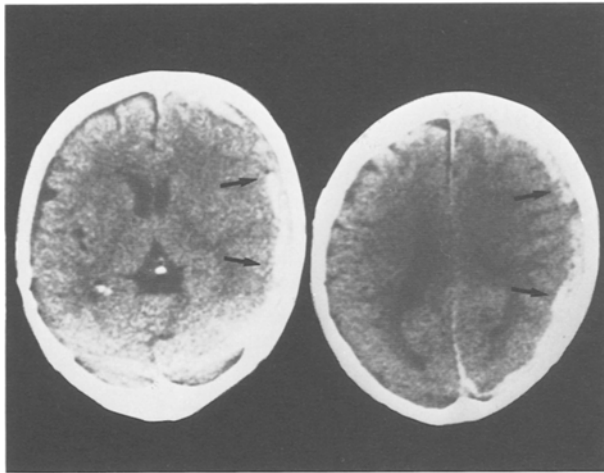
Computed tomography scans at the time of admission in case 1, showing a high density lesion covering the entire cerebral hemisphere on the left side (arrows)
